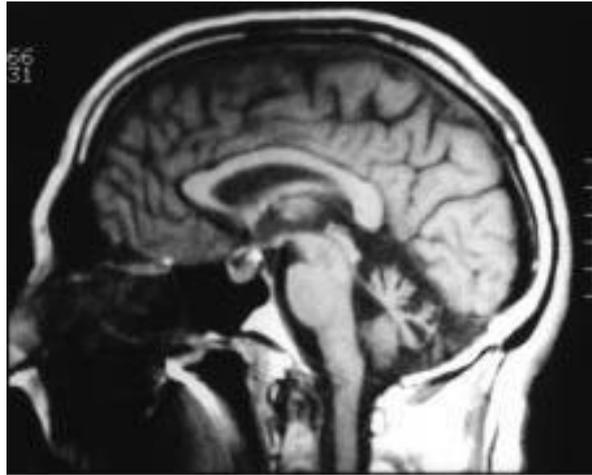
Brain MRI in sagittal section showing cerebellar atrophy
